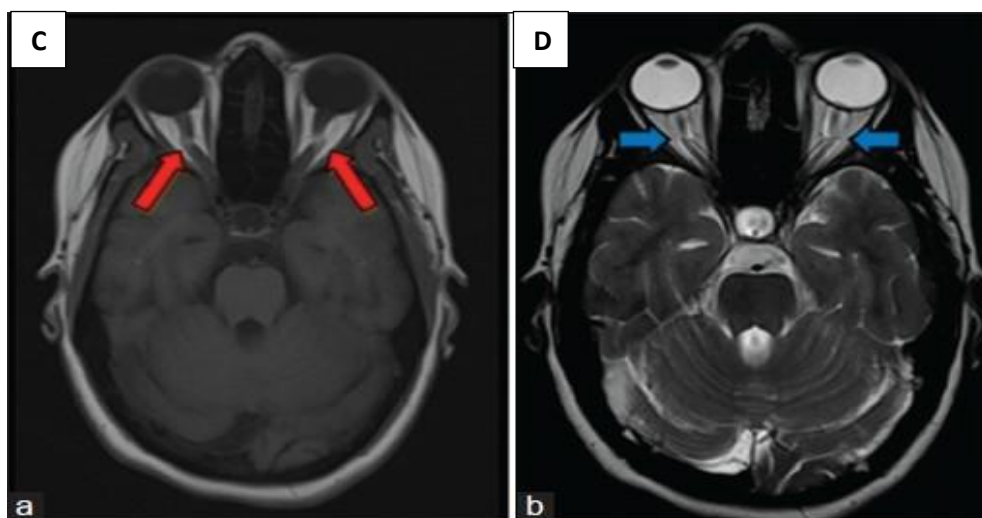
and 2D showing T1 and T2 Magnetic resonance imaging of brain with orbit axial section showing tortuosity of bilateral optic nerve (arrow)
